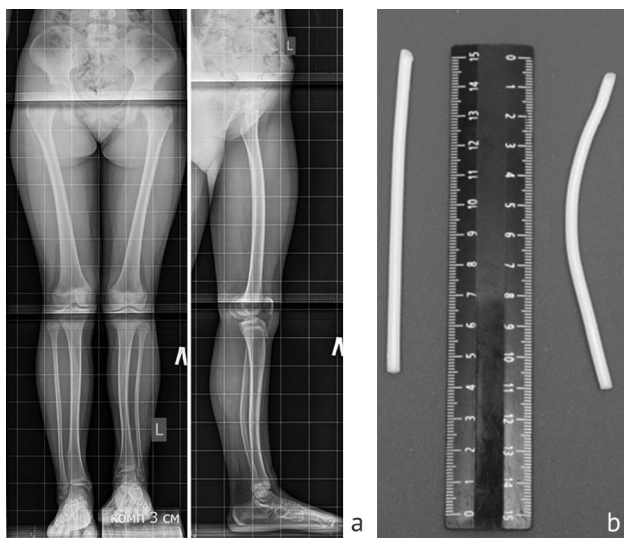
Preoperative period: a – standing radiographs of lower limb; b – biodegradable implants
